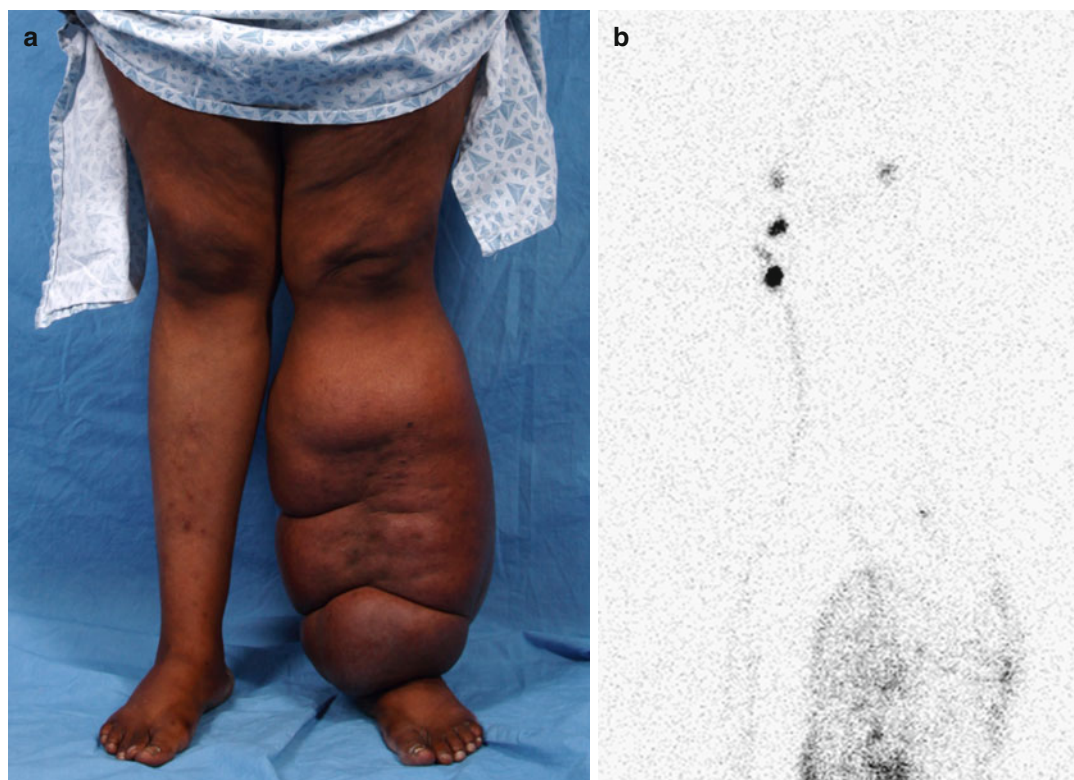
Lymphoscintigraphy to confirm the diagnosis of lymphedema. (a) A 30-year-old woman had experienced swelling of the left lower extremity since adolescence. (b) Lymphoscintigraphy is performed after intradermal injection of filtered ^{99m}Tc -labeled sulfur colloid in the dorsum of each foot. After 45 min, normal tracer accumulation is
